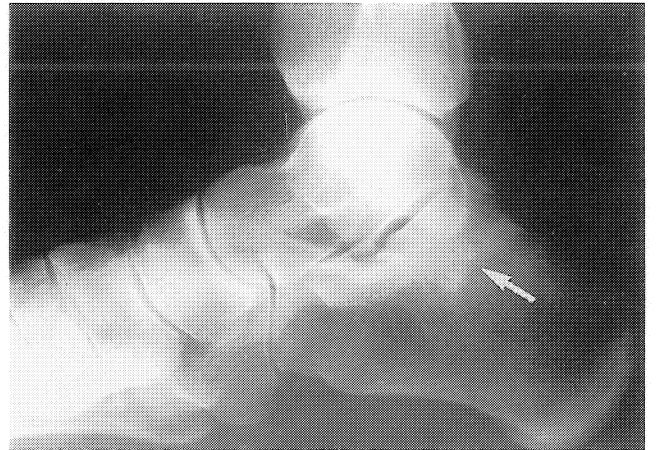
Repeat radiograph obtained at time of the bone scan shows a calcaneal stress fracture (arrow).
